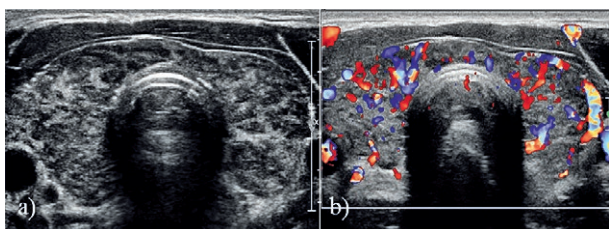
Hashimoto's thyroiditis – transverse scan through the neck shows a heterogeneous thyroid gland with multiple hypoechoic areas in it on the Bode image (a) and increased vascularity on the Color Doppler (b) image.
